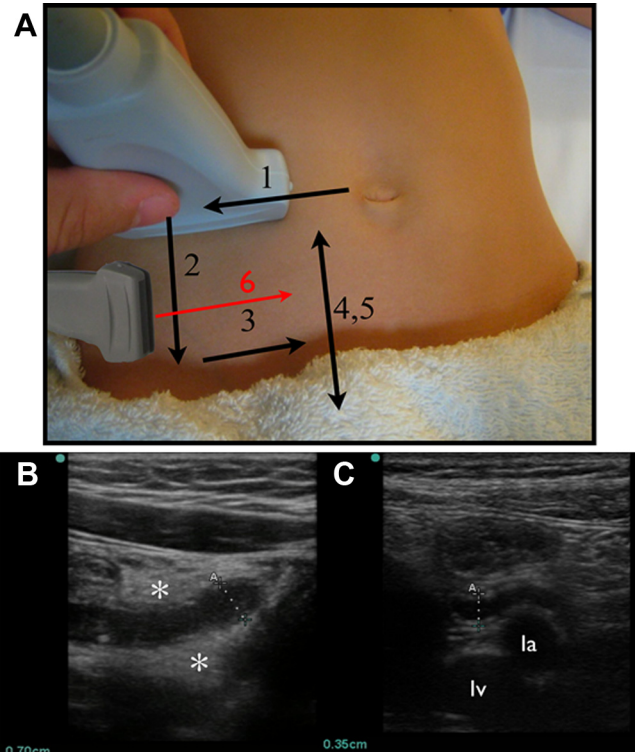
Ultrasonographic scanning protocol. A, With the probe initially in the transverse position at the level of the umbilicus and using compression, (1) move laterally to identify the lateral border of the ascending colon. (2) Move down the lateral border to the end of the cecum. (3) Move medially across the psoas and iliac vessels. (4, 5) Move down and up the border of the cecum. (6) With the probe in a sagittal position, identify the end of the cecum in the long axis and move medially across the psoas. B, Inflamed, dilated appendix (calipers A) with surrounding periappendiceal inflammation (*). C, Normal appendix (calipers A) overlying the la and lv. la, Iliac artery; lv, iliac vein.
